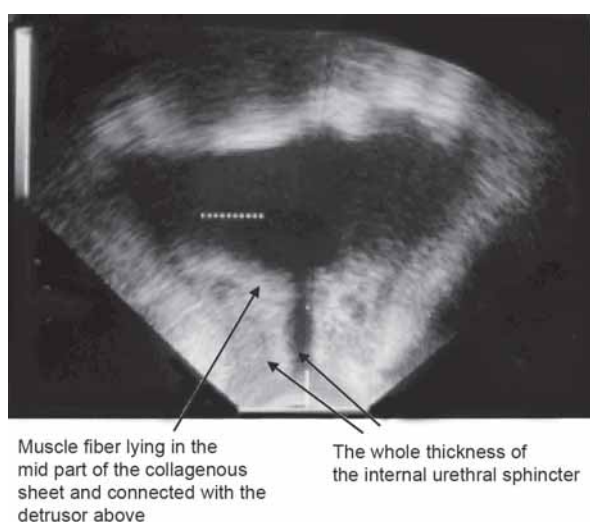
Ultrasound imaging by 3D US, coronal section of a normal intact IUS in a normal continent woman; kindly notice two echoes, muscle overlying collagen, and the muscle is connected above with the detrusor muscle
